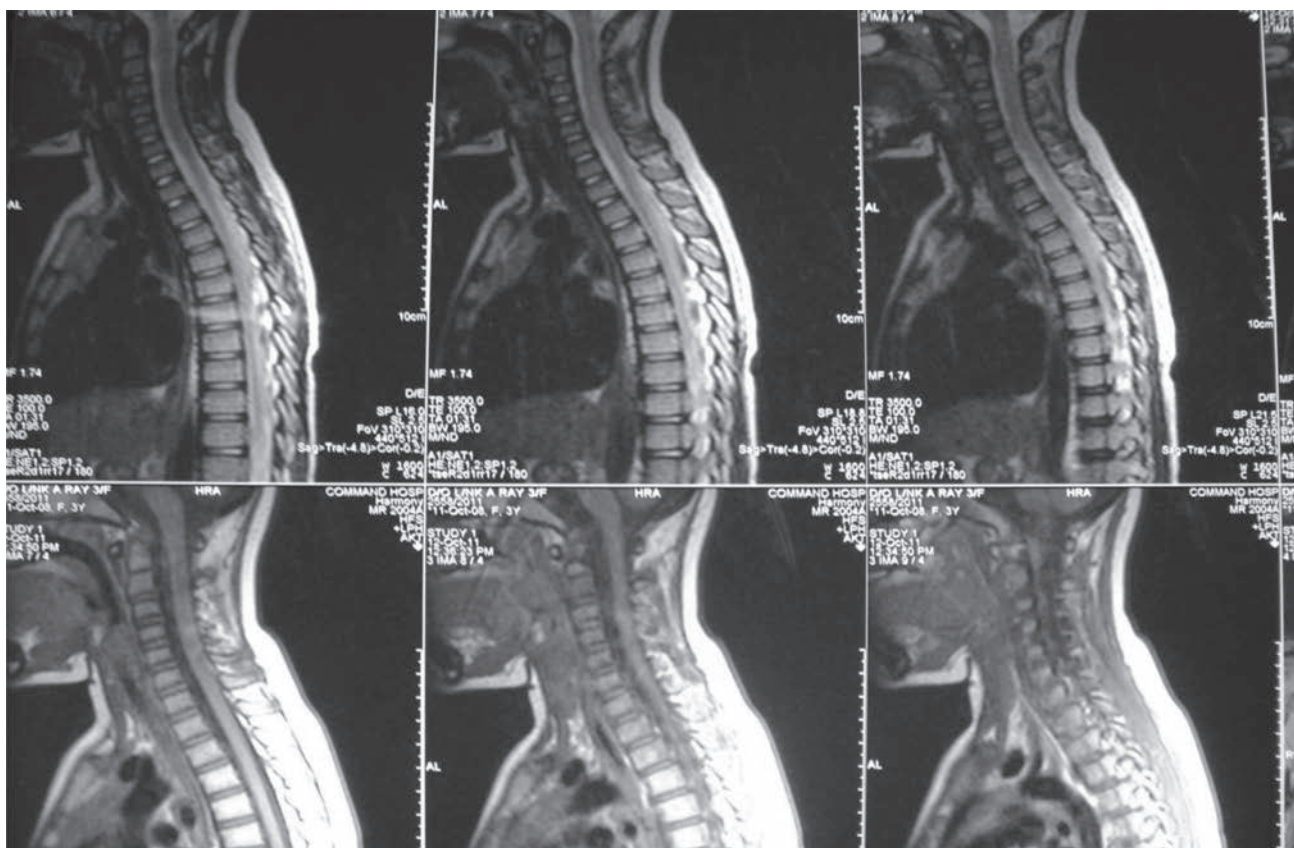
MRI cervical spine showing hyperintensities suggestive of myelopathy.
